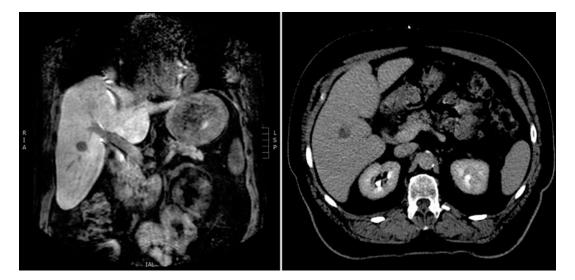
Solitary non-small-cell lung cancer liver metastasis. The lesion is depicted in a coronal reconstruction T1-weighted delayed-phase contrast-enhanced MRI, as well as a delayed-phase post-contrast axial CT. By size (10 mm) and location, this is a candidate lesion for
